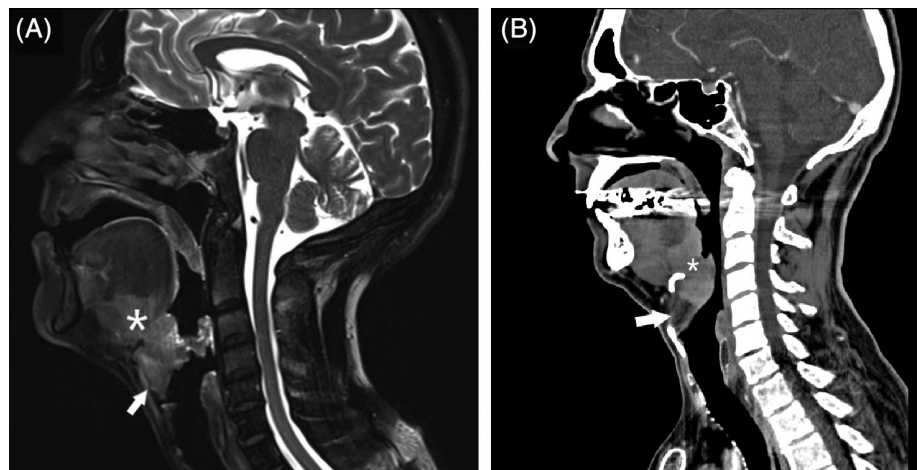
MR and CT image demonstrates a relative contraindication for transoral robotic surgery of the tongue base. A, Sagittal T2-weighted MR image. B, Sagittal contrast-enhanced CT images demonstrates a large tongue base mass (*) which extends inferiorly with pre-epiglottic fat involvement (white arrow)
